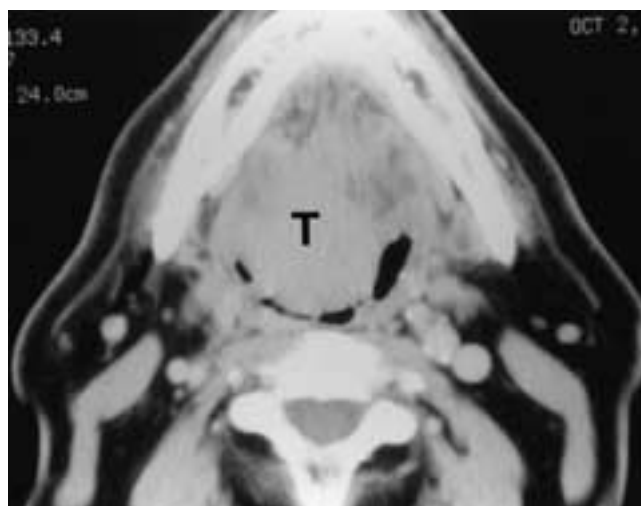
Axial contrast-enhanced CT scan shows a soft-tissue mass arising from the tongue base (*T*). Biopsy revealed a rhabdomyoma.
